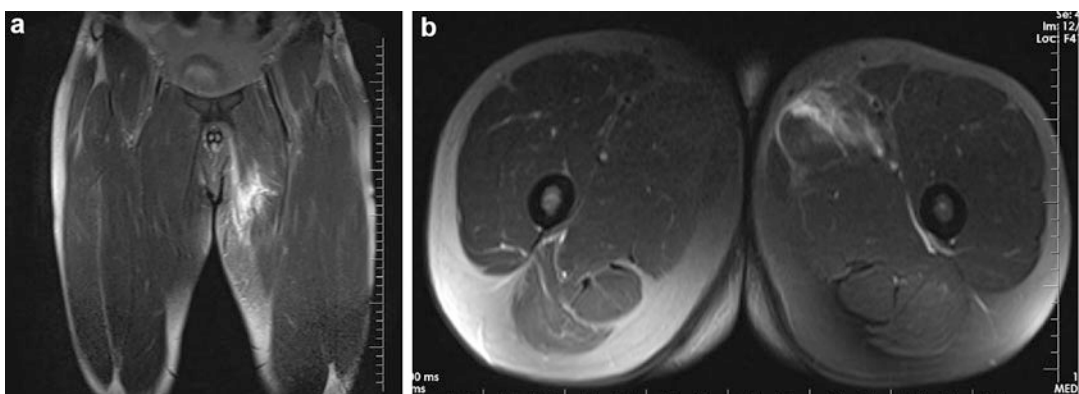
MR images of an amateur soccer player with acute groin pain. (a) T2-weighted coronal image showing left adductor longus muscle strain with mild feathery edema
